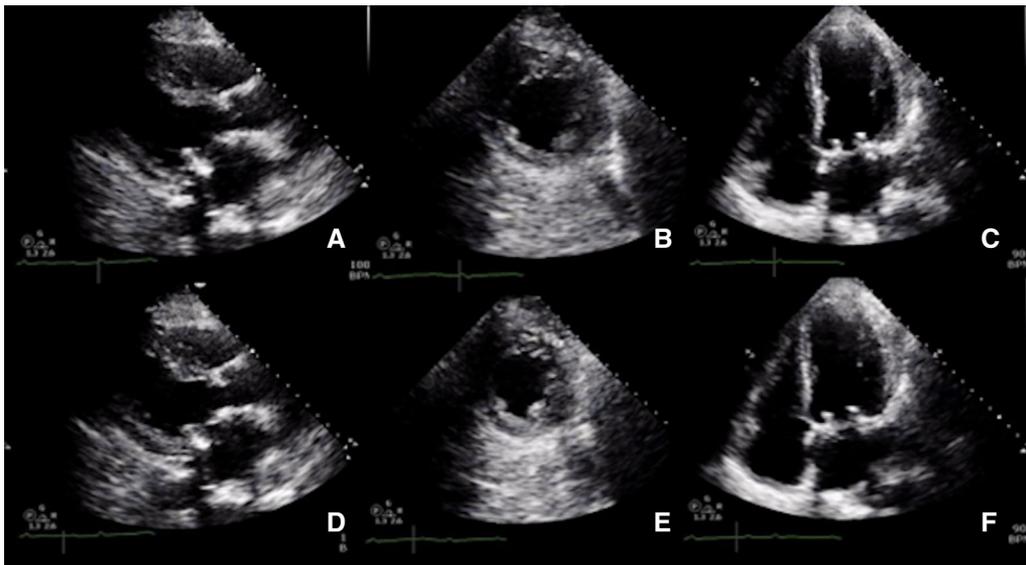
Transthoracic echocardiogram end-diastolic and end-systolic frames of parasternal long-axis (A, D), short-axis (B, E) and apical 4-chamber (C, F) views. The left ventricle was non-dilated with severely reduced left ventricular function. The right ventricle was normal in size and function. The mitral valve bioprosthesis was normal in function without mitral regurgitation.
